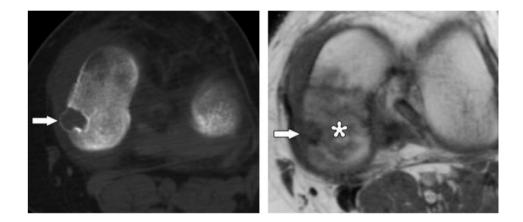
Chondroblastoma of the left medial femoral condyle – Axial plain CT shows an eccentrically placed epiphyseal lucent lesion (arrow) with expanded cortex. Axial T1W MR image reveals the low intense lesion (arrow) with adjacent bone marrow edema (*) (4).
